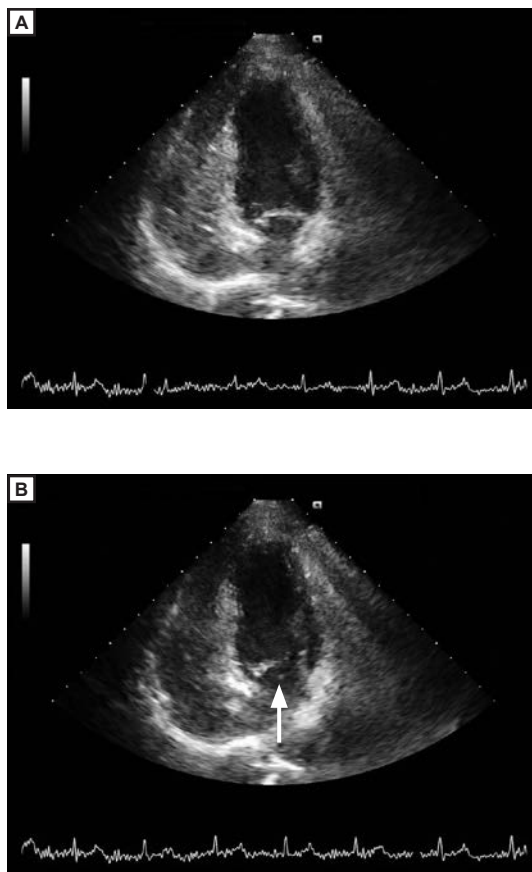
Transthoracic echocardiographic image (A) and while performing the Valsalva maneuver (B) shows a patent foramen ovale (arrow) in a patient presenting with neurologic symptoms after foam sclerotherapy.
